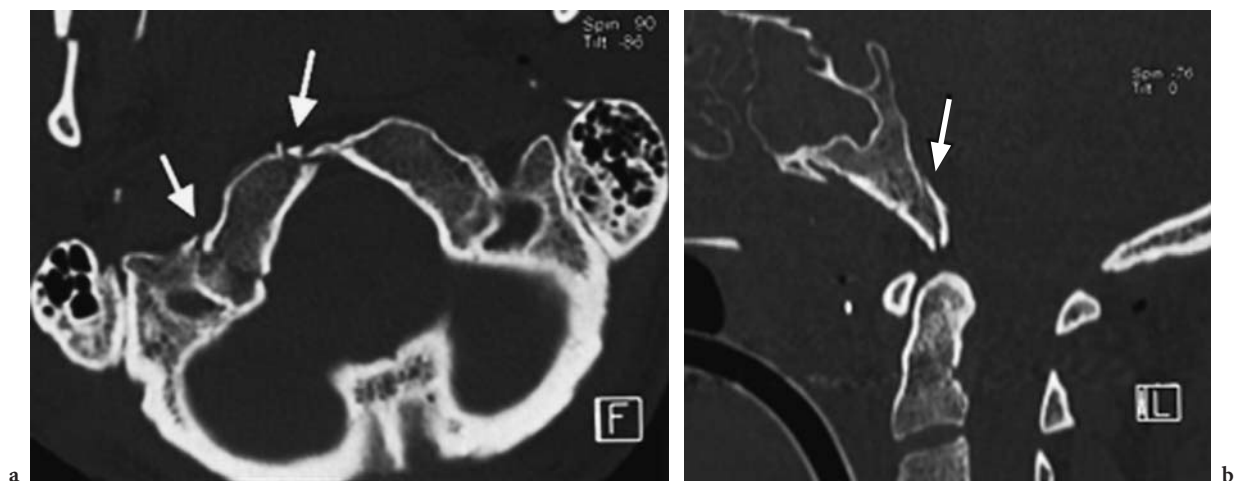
Condylar fracture: type III, unstable type. a Axial CT image. b Sagittal CT reformation. Multiple condylar fractures (arrows) extending to the clivus (arrow)
